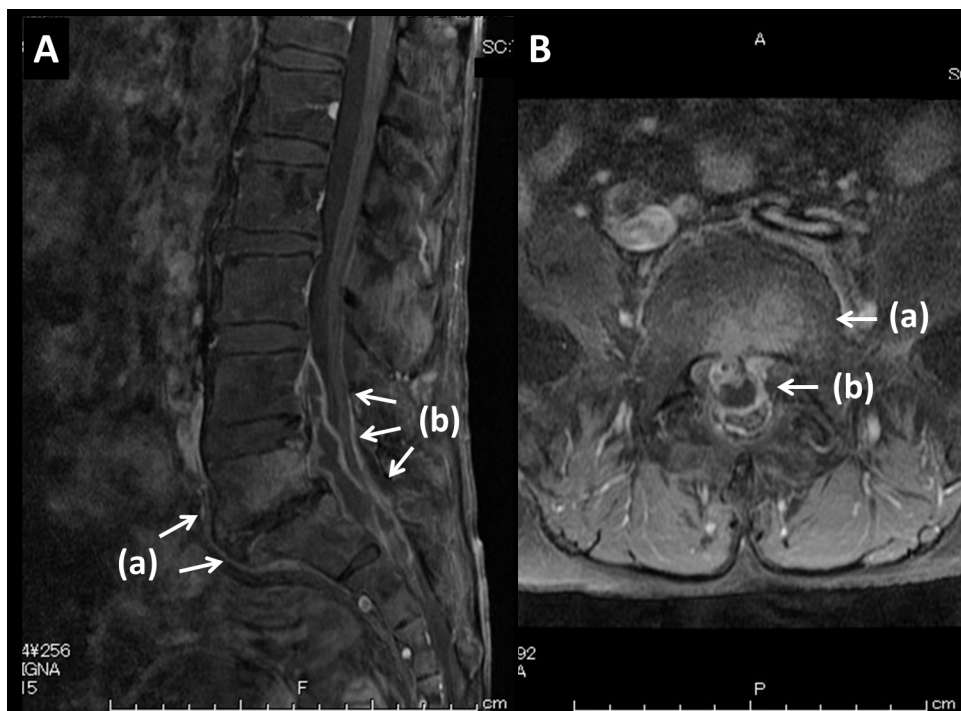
Magnetic resonance imaging (MRI) scan of the lumbar vertebrae showing sagittal (a) and horizontal (b) sections. An MRI scan showing contrast enhancement in the lumbar and sacral vertebrae (L5 and S1, arrow a), destruction of the L5/S1 intervertebral disc, and spinal epidural abscess at the L4–S1 level (arrow b).
